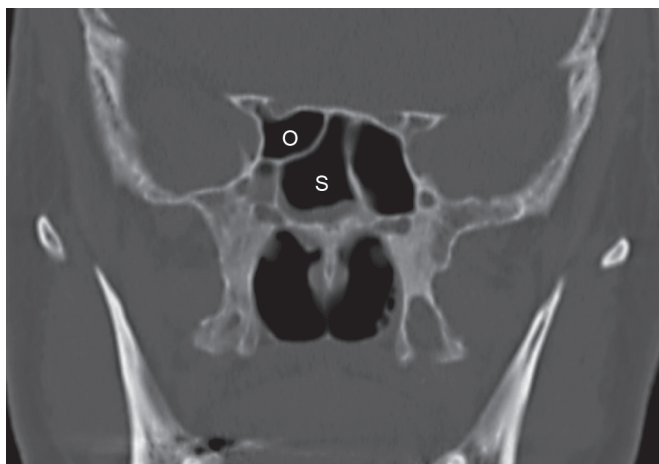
Coronal computed tomography (CT) scan image in a bone window algorithm showing right sphenothmoidal air cells (Onodi cells; O), which can be seen superior and lateral to the sphenoid sinus (S). The optic nerve and carotid artery are seen as bony protrusions in the sphenothmoidal air cells, rather than along the lateral wall of the left sphenoid sinus.
